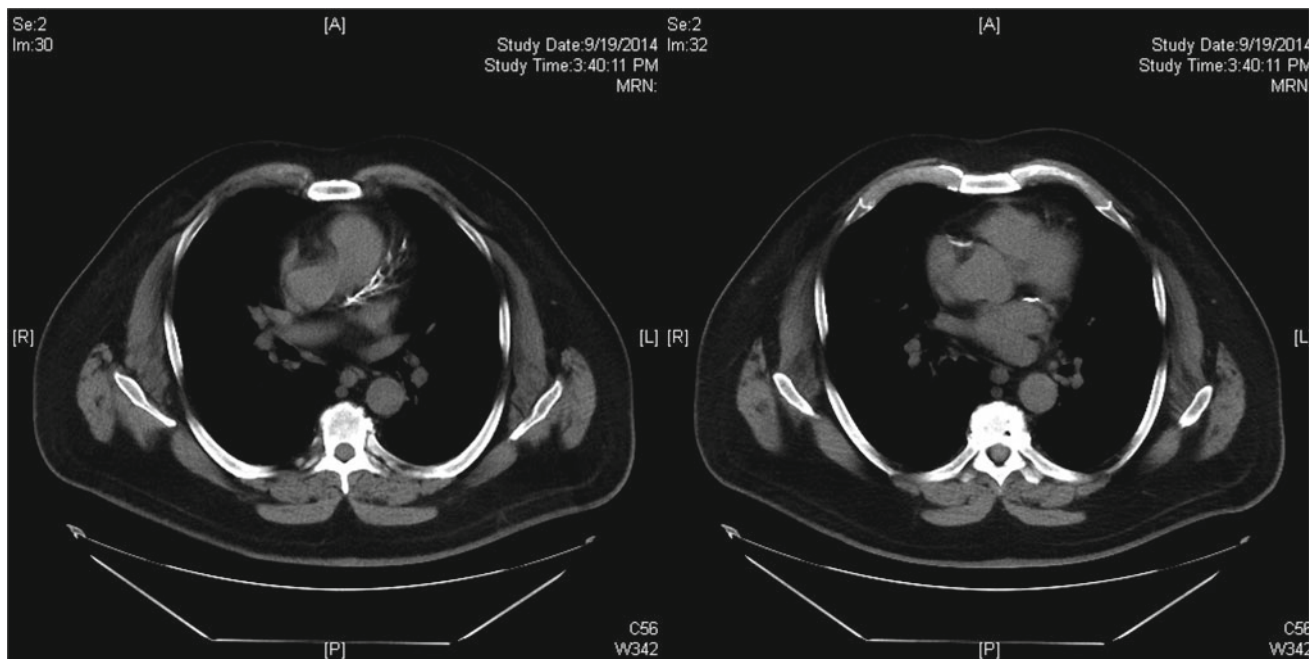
Extensive coronary calcium seen on the patient's staging CT of chest/abdomen/pelvis
